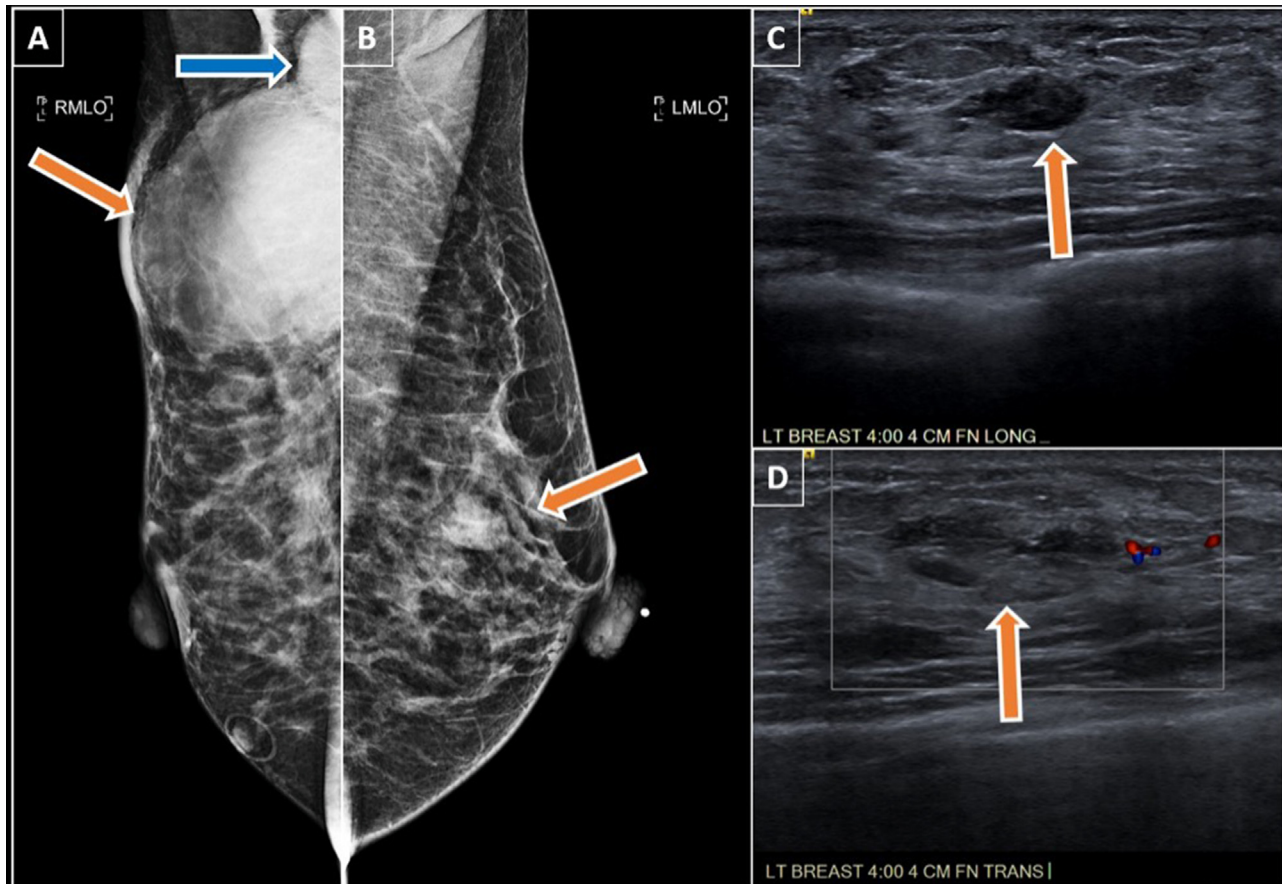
Image (A) right breast mediolateral oblique mammogram view demonstrates a large high-density mass (orange arrow) in posterior upper right breast measuring approximately 8 cm. Right axillary lymphadenopathy also noted (blue arrow). Image (B) left breast mediolateral oblique mammogram view demonstrates an oval circumscribed mass (orange arrow) in the left breast, measuring up to 1.8 cm. Images (C) and (D) are the longitudinal and transverse sonographic views of the oval left breast mass (orange arrows).
